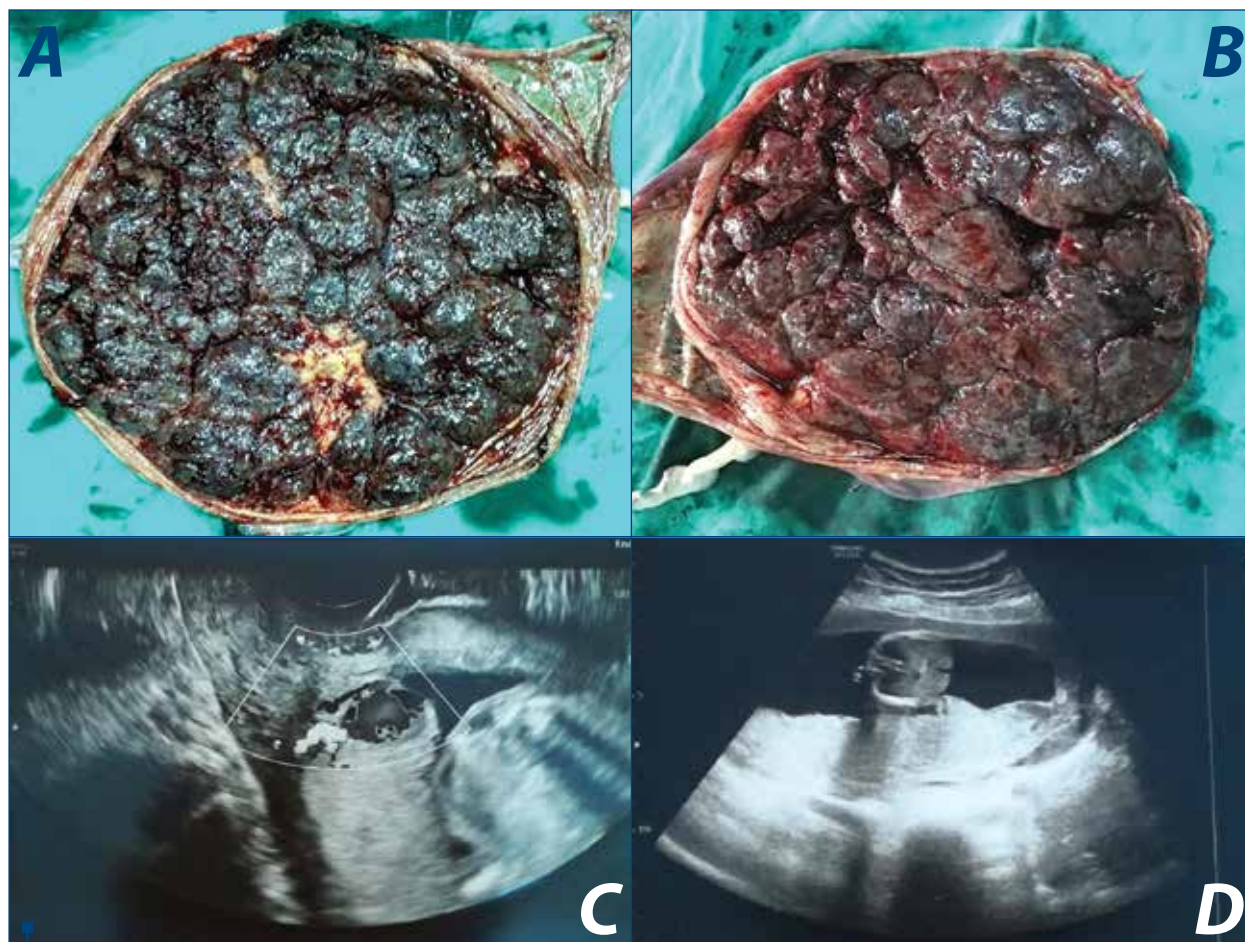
Macroscopic (A and B) up – calcifications and atherosclerosis and ultrasonographic (C and D) down – venous lakes placental images from patients with thrombophilia
